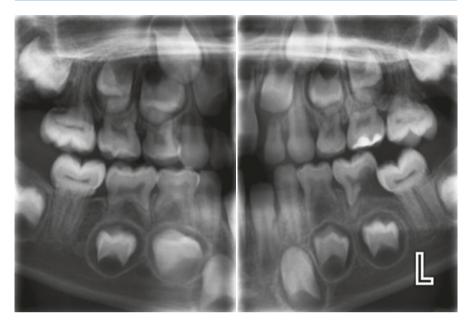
These extraoral bitewing radiographs taken on a 7-year-old boy with dentinal dysplasia show clearly the thistle-shaped pulp chambers in the first permanent molars, which also appear to have poorly developed roots (courtesy of Dr. Elise Sarvas, USA)
